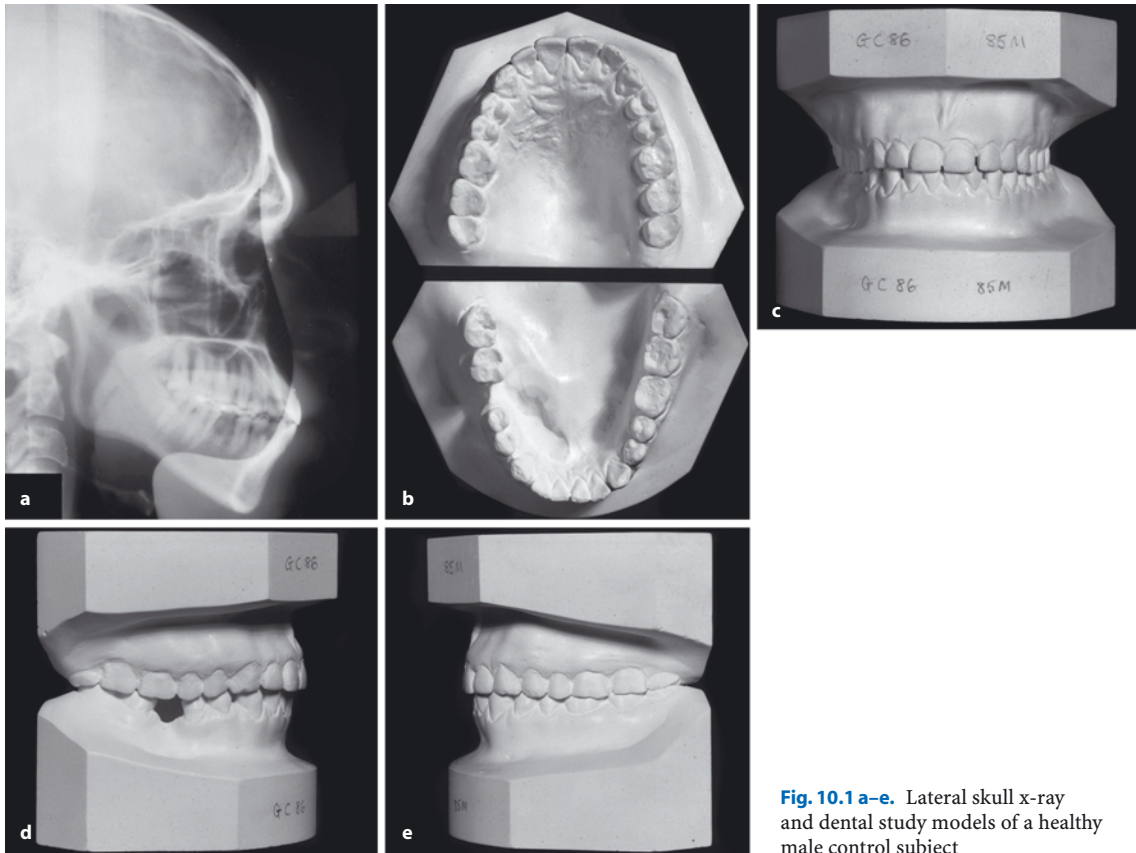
a–e. Lateral skull x-ray and dental study models of a healthy male control subject
